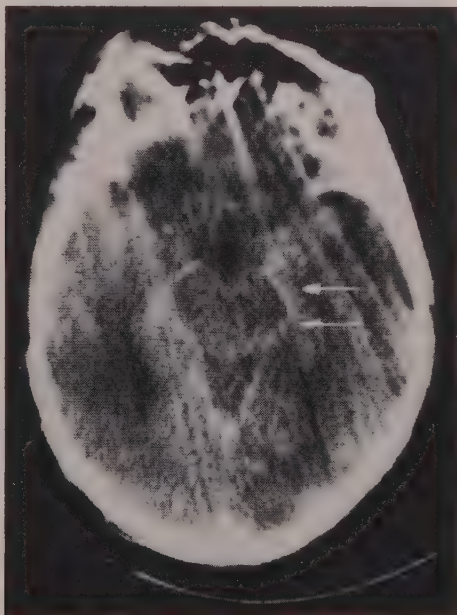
A contrast-enhanced CT scan in a patient with leptomeningeal metastases. In this patient, contrast enhancement of the basal cisterns (arrows) was instrumental in establishing the diagnosis of leptomeningeal metastases.
